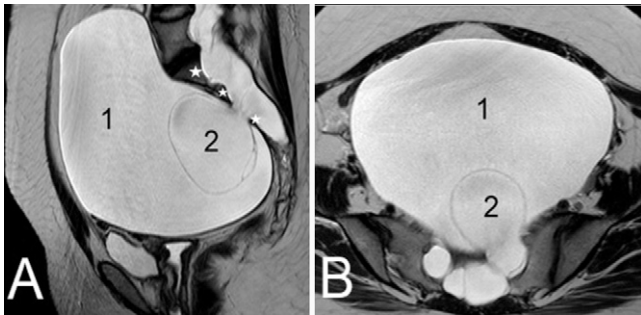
T2-weighted MRI of the pelvis showing anterior sacral meningocele with two cystic cavities (1 and 2), with connection to the spinal space S2-S3 (A, 2nd and 3rd white stars).
